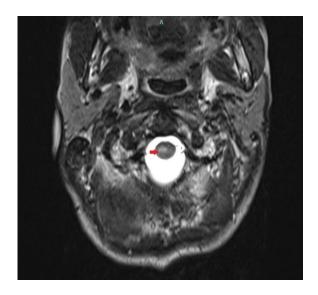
Axial T2W MRI with hyper-intense signals at C5.
